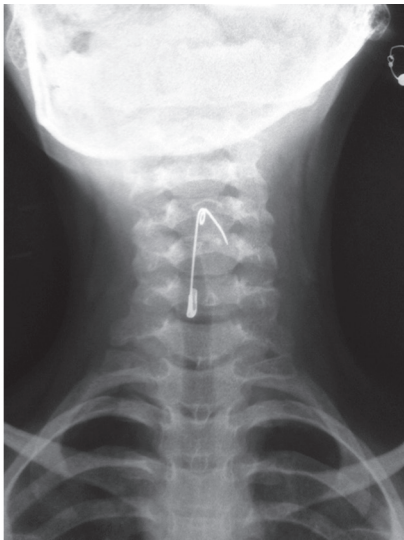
X-ray neck (AP view) showing open safety pin
